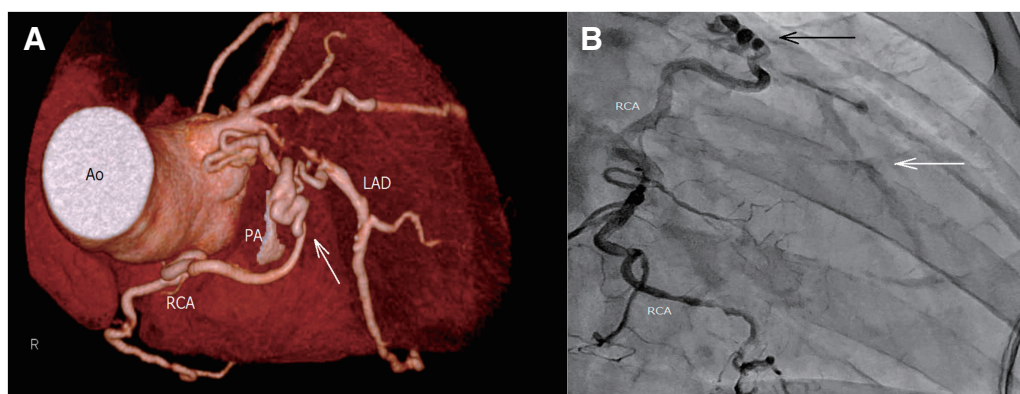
(A) Coronal CT angiography showing occlusion of the proximal LAD. Abnormal, tortuous vessels appear to be connected to a conus branch of the RCA, the LAD distal to the occlusion, and the left sinus of Valsalva (white arrow). (B) Right coronary angiography shows that the fistula (black arrow) originates from the conus branch of the RCA to the main pulmonary artery, supplying collateral blood flow to the distal segment of the LAD (white arrow). CT: computed tomography; RCA: right coronary artery; LAD: left anterior descending artery
